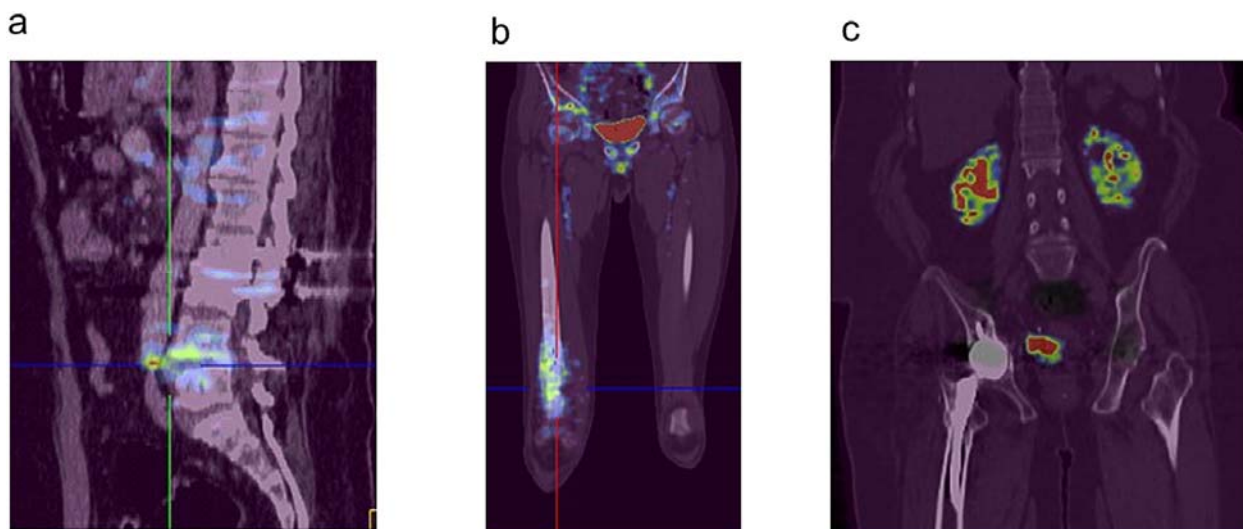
$[^{68}\text{Ga}]\text{Ga-NOTA-UBI29-41 PET/CT}$ images showing a) true positive scan for TB spine infection b) true positive scan for infection in right thigh and c) true negative scan for suspected prosthesis infection (provided by A. Mukherjee, as previously published in *Journal of Pharmaceutical and Biomedical Analysis* [37])
